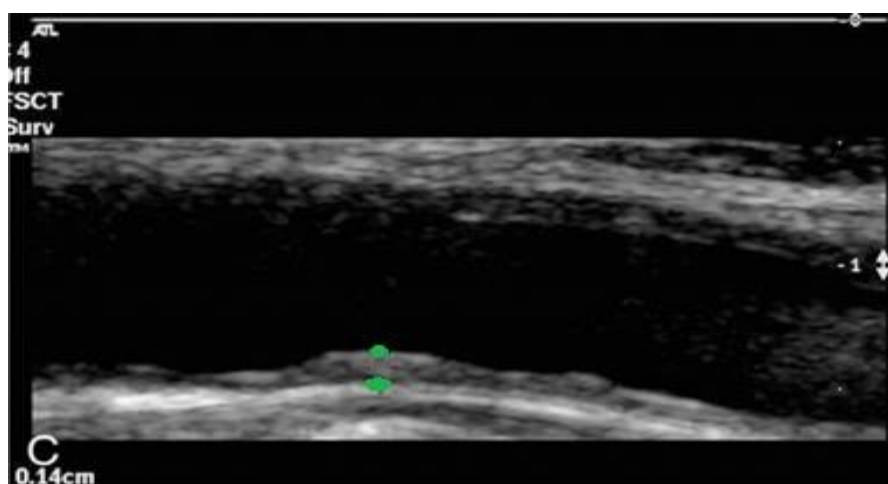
Doppler images showing various changes in CIMT
